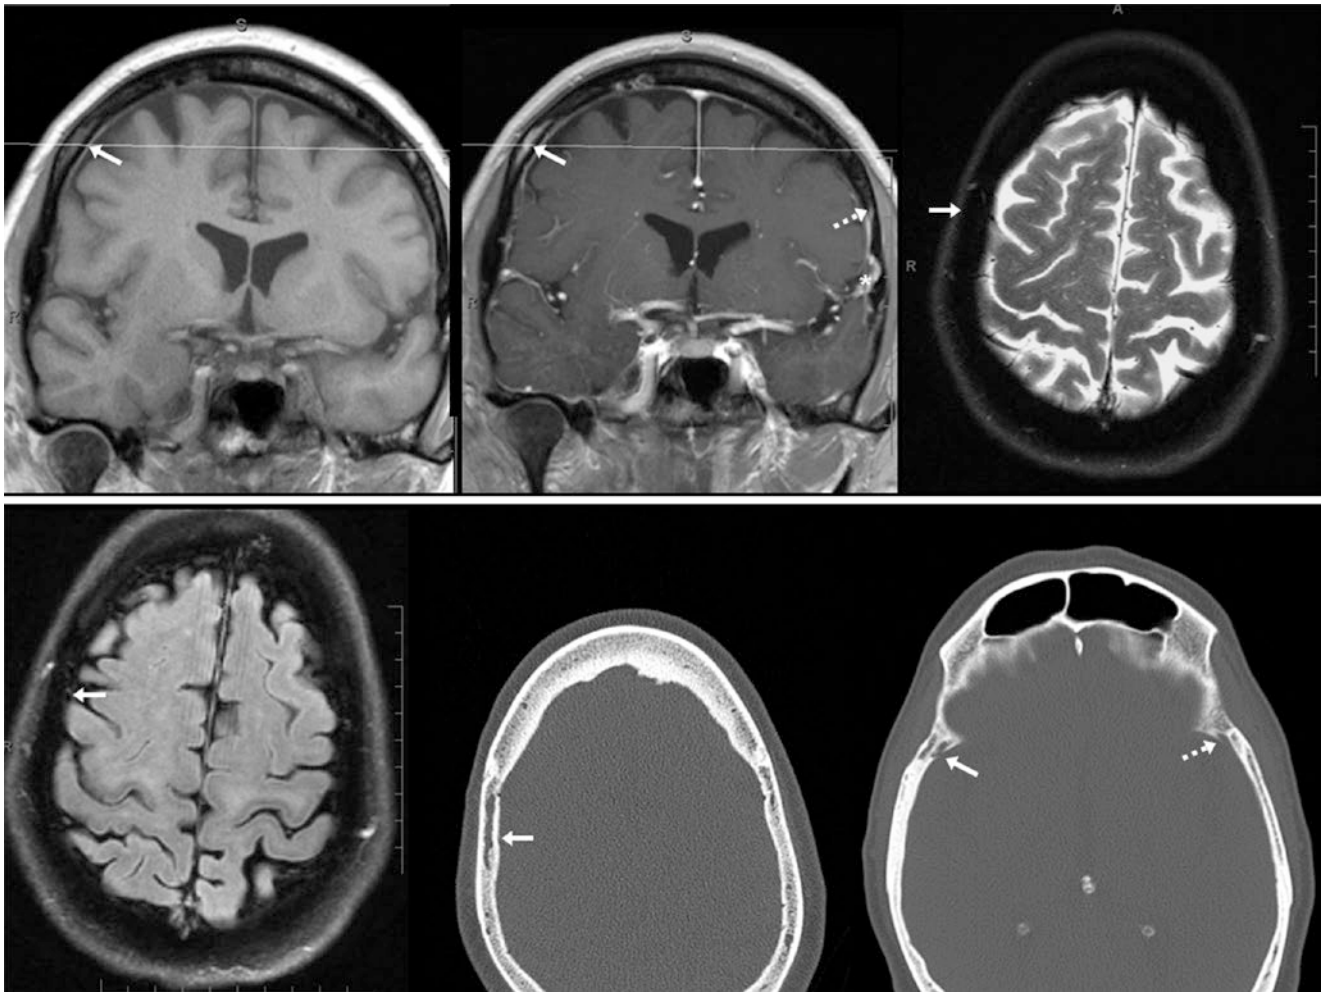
A 52 year old: an ovoid-enhancing focus (arrows) on post-contrast T1WI (top middle) was not visualized on either fat-suppressed T2WI (top right) or FLAIR (bottom left). Scout lines (top row) confirmed the location. CT depicted a prominent vascular channel (bottom
